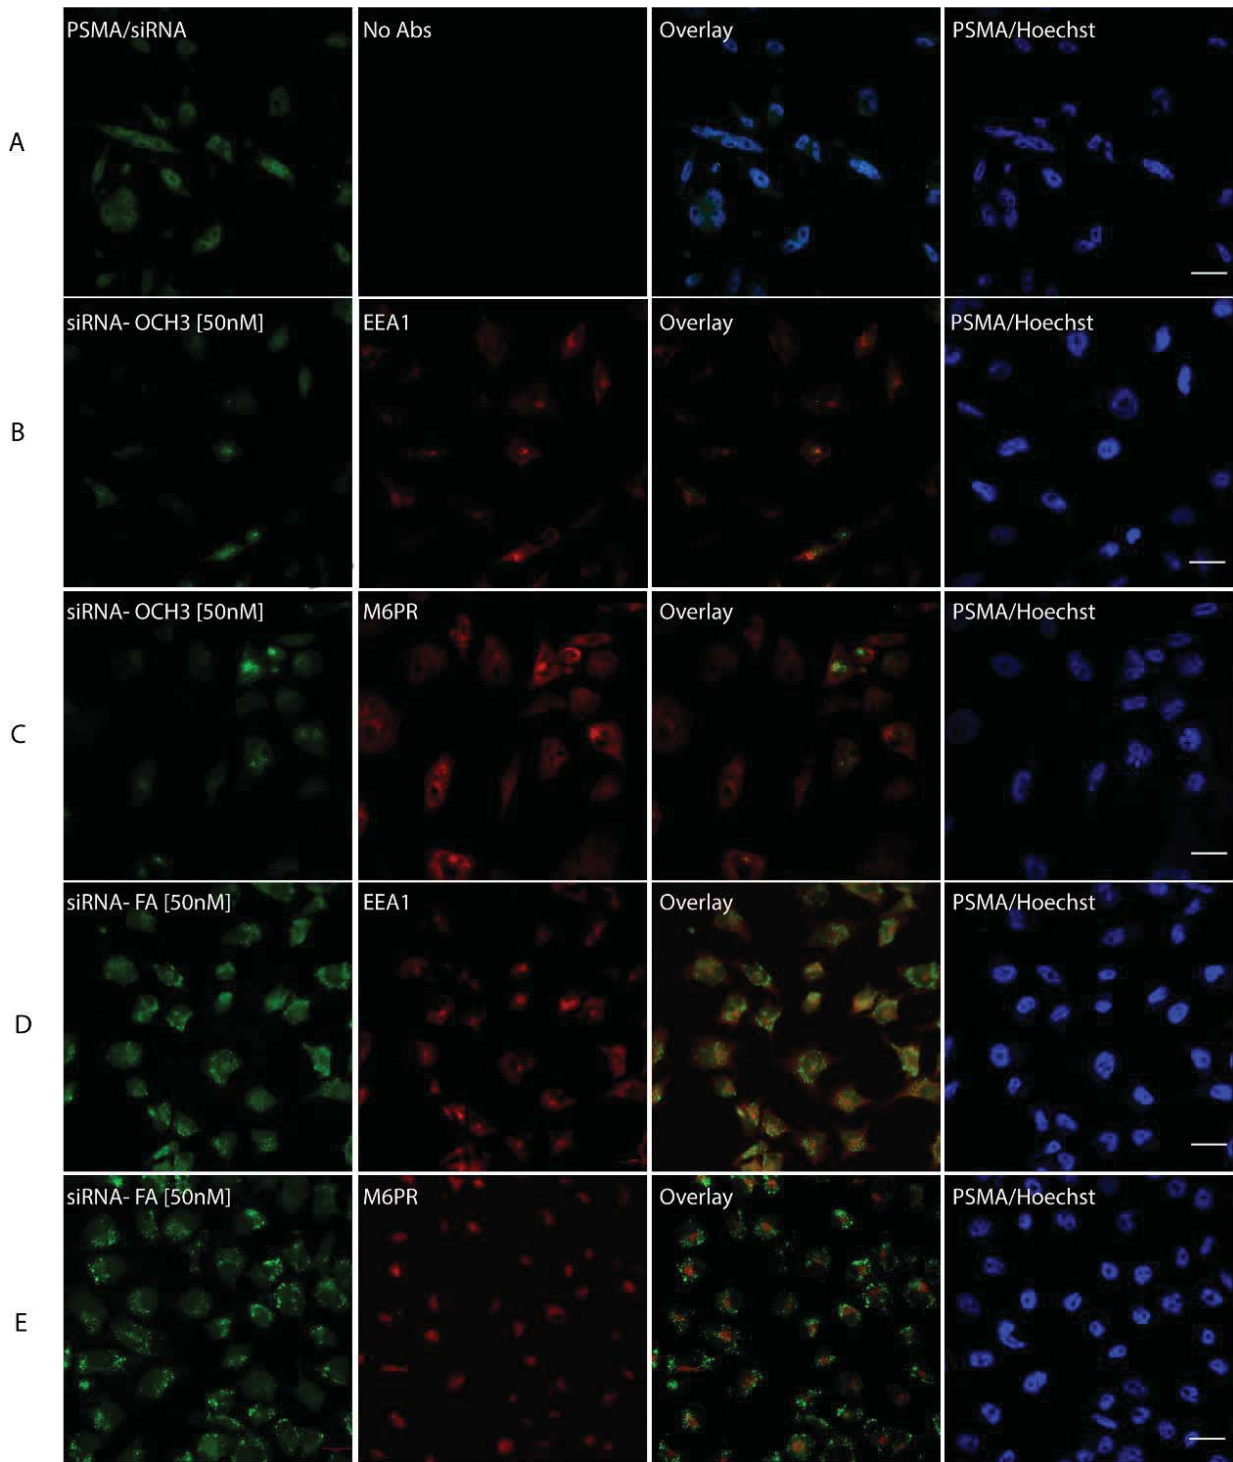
siRNA intracellular localization. PC3-PSMA cells were incubated for 4 hours with siRNA.NP complexes tagged with either -OCH3 (B, C) or -FA (D, E) at 37 °C. Panel A serves as a control, where PC3-PSMA cells were incubated with 50nM siRNA only. Cells were fixed in 100%
